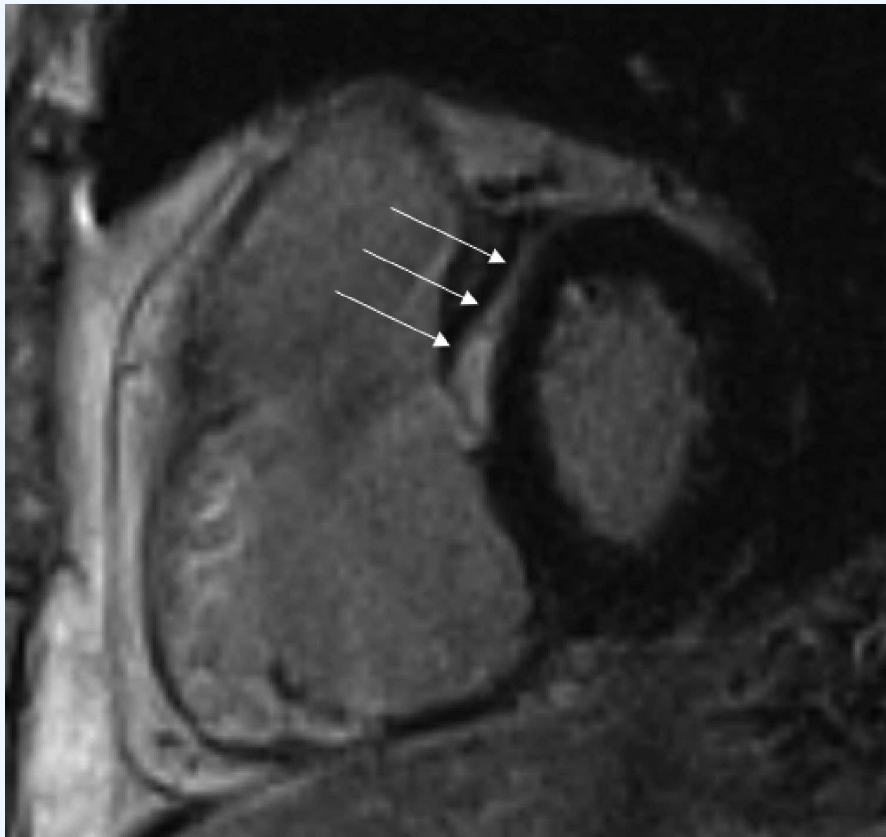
Cardiac magnetic resonance image (MRI). Shown is an MRI of the heart with the right ventricle on the left and the left ventricle on the right. Between the ventricles (arrows) is a stripe of late gadolinium enhancement, indicating midmyocardial fibrosis in the interventricular septum. This type of scar pattern is often seen in patients with nonischemic cardiomyopathies and ventricular tachycardia.
